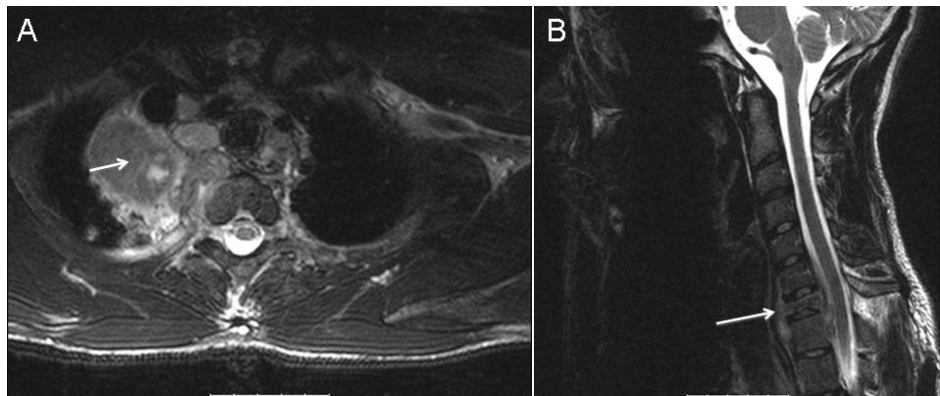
MRI C-spine (axial T2-weighted images). Panel A: soft tissue marrow edema surrounding the posterior process of the C7 vertebral body and it's contiguous with a heterogeneous infiltrative process of the right medial lung apex (arrow). Panel B: C7 vertebral body compression (arrow).
